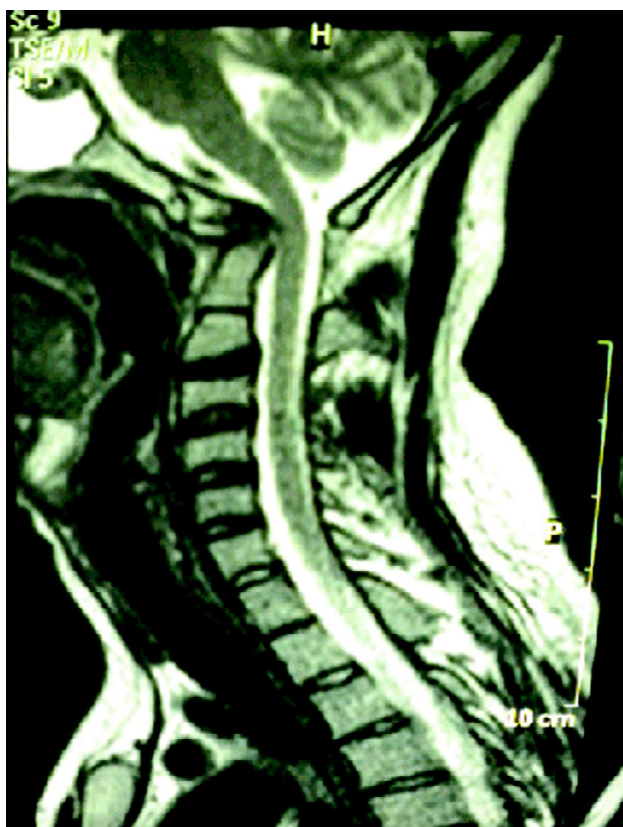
T2 weighted MRI cervical spine (sagittal section) showing indentation of the cervico-medullary junction by the odontoid process.
